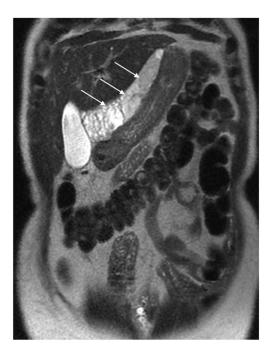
MRI examination. The coronal T2-weighted image shows a multilobulated mass (arrows), located between the inferior part of the liver lobe and the small gastric curvature; the hyperintense signal is similar to that of a lymphangioma.
